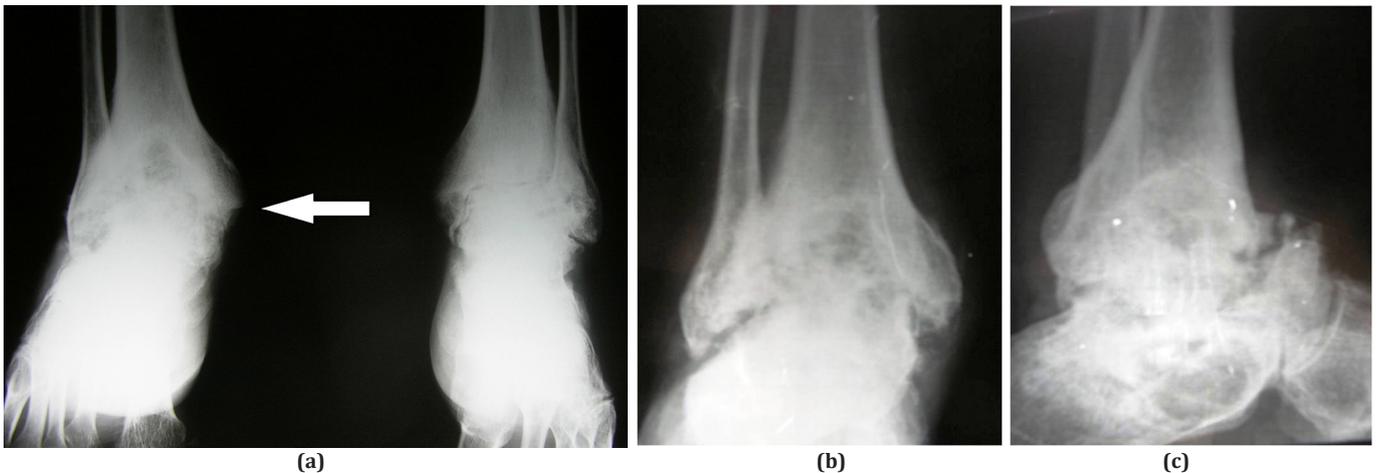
a-c. Tibiotalar arthrodesis performed using a closed retrograde locked intramedullary nail in an adult patient with hemophilia with inhibitor. The indication was the presence of severe pain and recurrent hemorrhage. The result was satisfactory: (a) preoperative anteroposterior radiograph of both ankles, showing advanced bilateral arthropathy, more intense on the right side (arrow); (b) preoperative anteroposterior image centered on the right ankle; (c) preoperative lateral radiograph of the right ankle.
